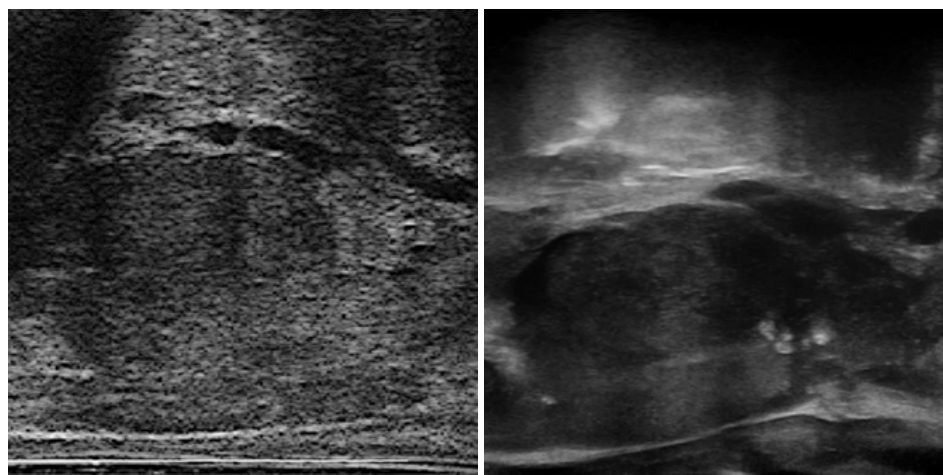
Comparison between RF-reconstructed (left) and native B-mode (right) ultrasound images
